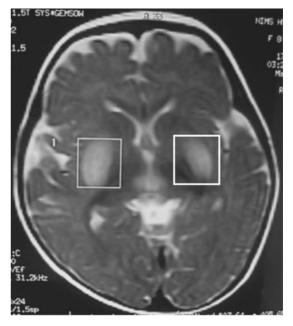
Magnetic resonance imaging (MRI) picture of a patient showing characteristic bilaterally symmetrical hyper intense lesions in the basal ganglia. The rectangles indicate the lesions on either side.
